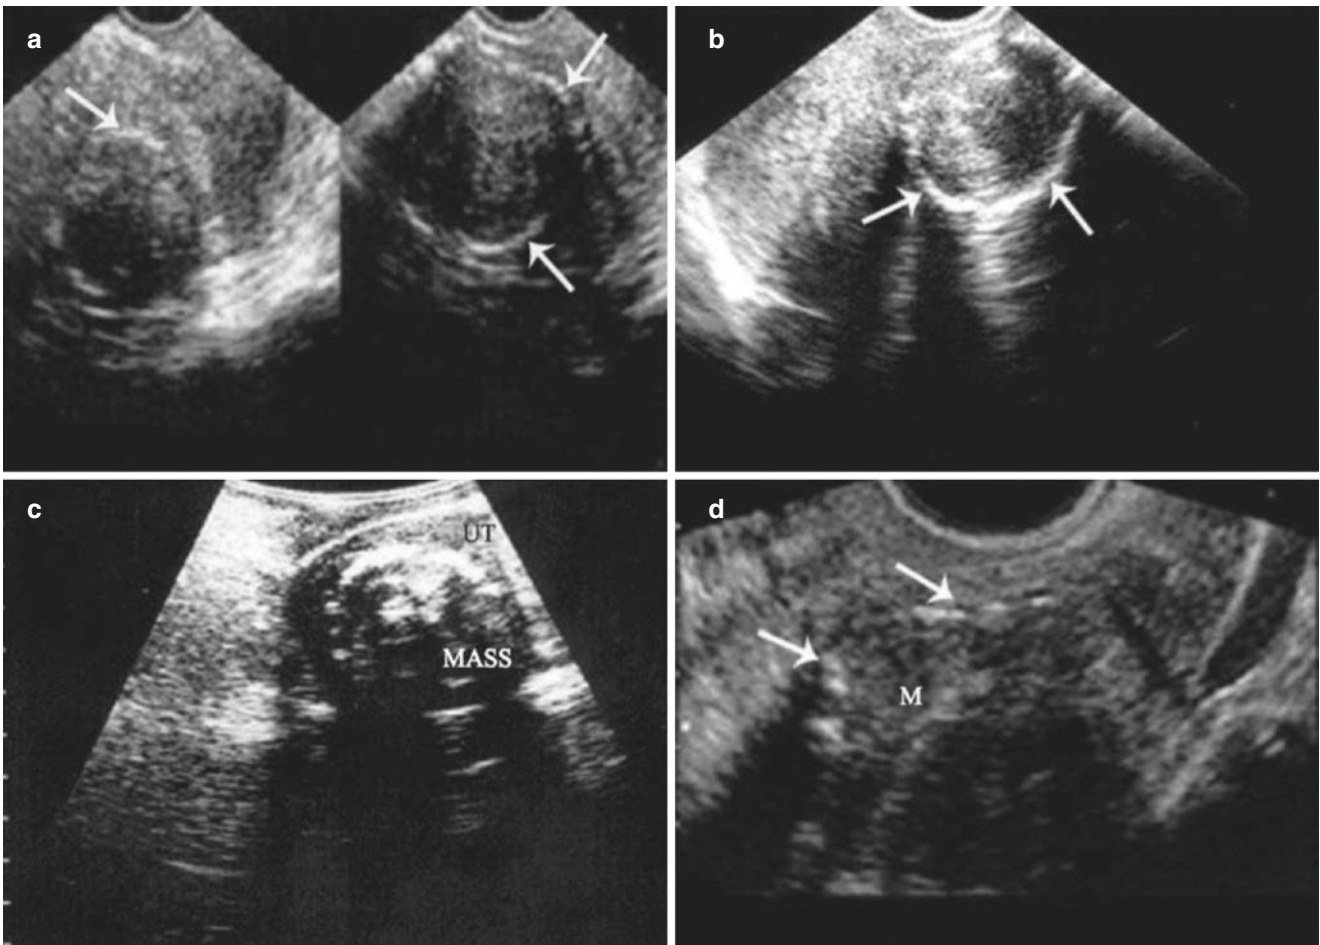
Calcified leiomyoma. (a, b) Leiomyoma with peripheral calcification. (c, d) Hyperechoic plaque accompanied by attenuated shadowing within the mass shown by sonogram. Arrow shows the calcification
